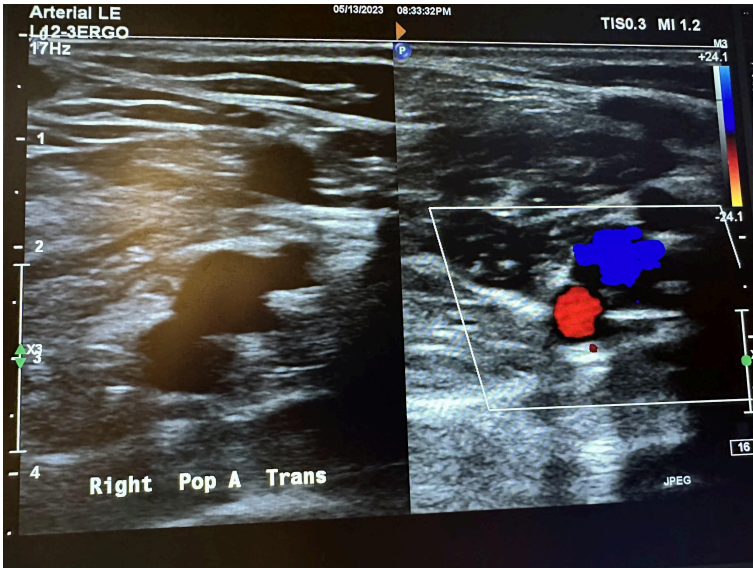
Side-by-side transverse images of the right popliteal artery without color Doppler and with color Doppler.
